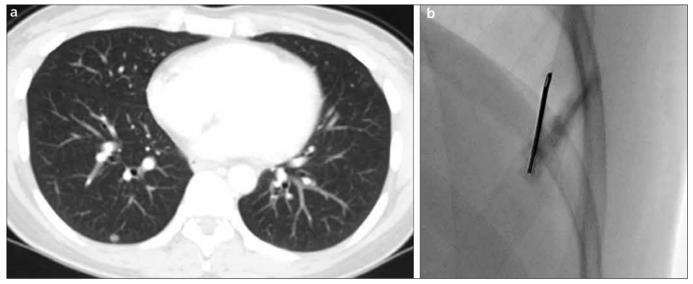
a, b. CT (a) shows a pulmonary nodule approximately 9 mm in diameter in the right lower lobe of a 38-year-old female. Fluoroscopy-guided percutaneous core needle biopsy of the solid nodule using an automated gun (b) revealed metastasis from a leiomyosarcoma based on pathological examination.
